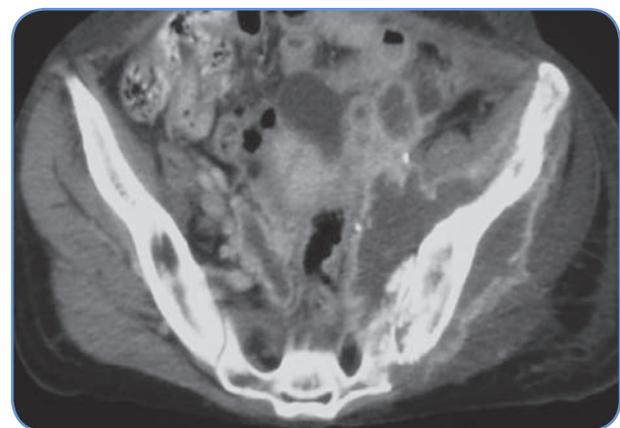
CT scan showing a pelvic side wall cervical cancer recurrence
